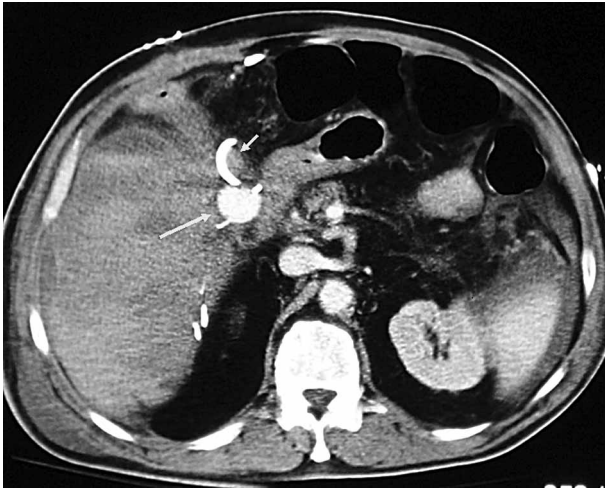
Contrast enhanced CT demonstrating 2.5-cm hepatic artery aneurysm (long arrow) and adjacent biliary stent (short arrow). The patient is status post bile duct resection and biliary reconstruction.
